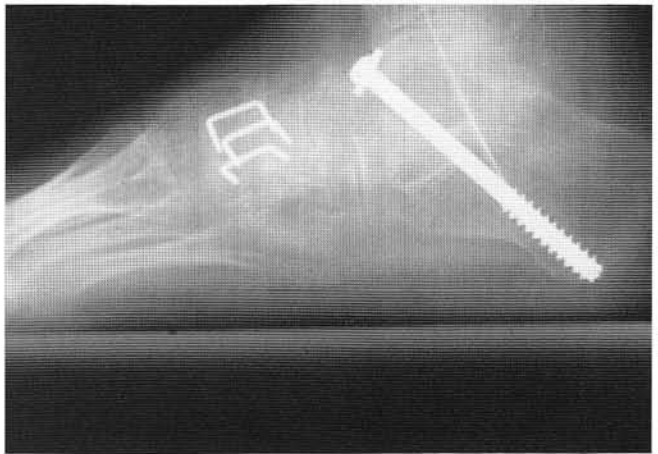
Eight-week lateral postoperative radiograph.
